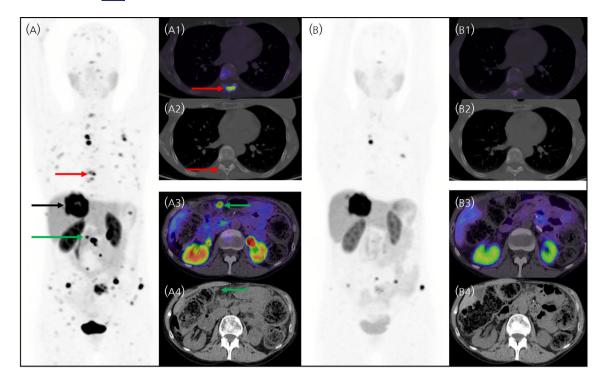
Case showing the role of multi-modality imaging for assessment post-PRRT, highlighting the importance of SSTR PET/CT in the diagnosis and response assessment of osseous disease. 63 years old female with metastatic Grade 2 small intestinal NEN. Pre-PRRT ⁶⁸Ga-DOTATATE PET/CT maximum intensity projection (MIP) images (A): Showed dominant RECIST 1.1 measurable liver metastases (black arrow); but multiple small osseous and nodal involvement were non-measurable on CT, and these were apparent on SSTR imaging. Images A1, A2: Representative small SSTR expressing bone metastases, not visible on CT. Images A3, A4: A small peritoneal metastasis was identified on SSTR imaging, this was non-enlarged and only retrospectively identified on CT. Post PRRT MIP images (B) showed overall reduction of SSTR disease burden. Whilst the dominant liver metastases remain stable based on RECIST 1.1, the other small non-measurable bone and nodal lesions have significantly reduced in avidity and number on PET/CT. Image B1, B2: The bone metastases remain occult on CT. Image B3, B4: The small peritoneal nodule became non-visible. This was accompanied by improvement of symptoms (bone pain), significant improvement of hormone secretory symptoms (flushing and diarrhoea), and reduction of CgA from 821 to 200 μg/L.
